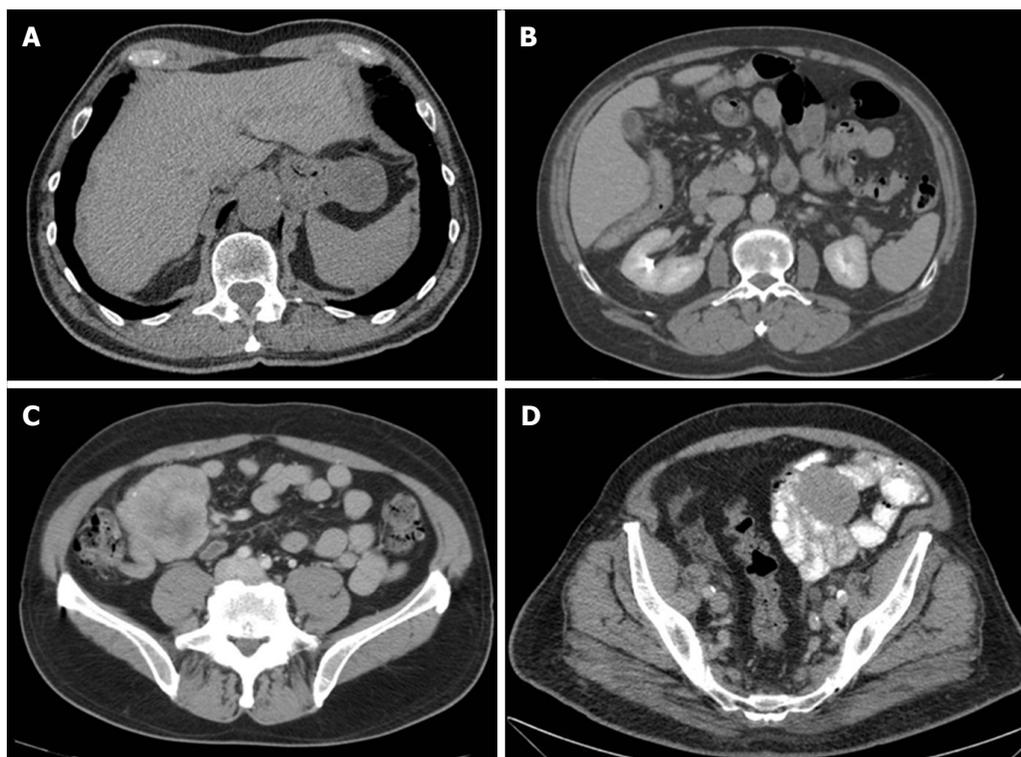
Localized gastrointestinal stromal tumors on computed tomography scan. A: Gastric; B: Duodenal; C: Ileal; D: Jejunal. A and B show respectively a gastric tumor and a duodenal tumor of exophytic growth with well-defined borders. Appreciate in C the different densities inside the tumor due to necrosis, haemorrhage, or degenerative components. D shows a jejunal GIST in left iliac fossa.
